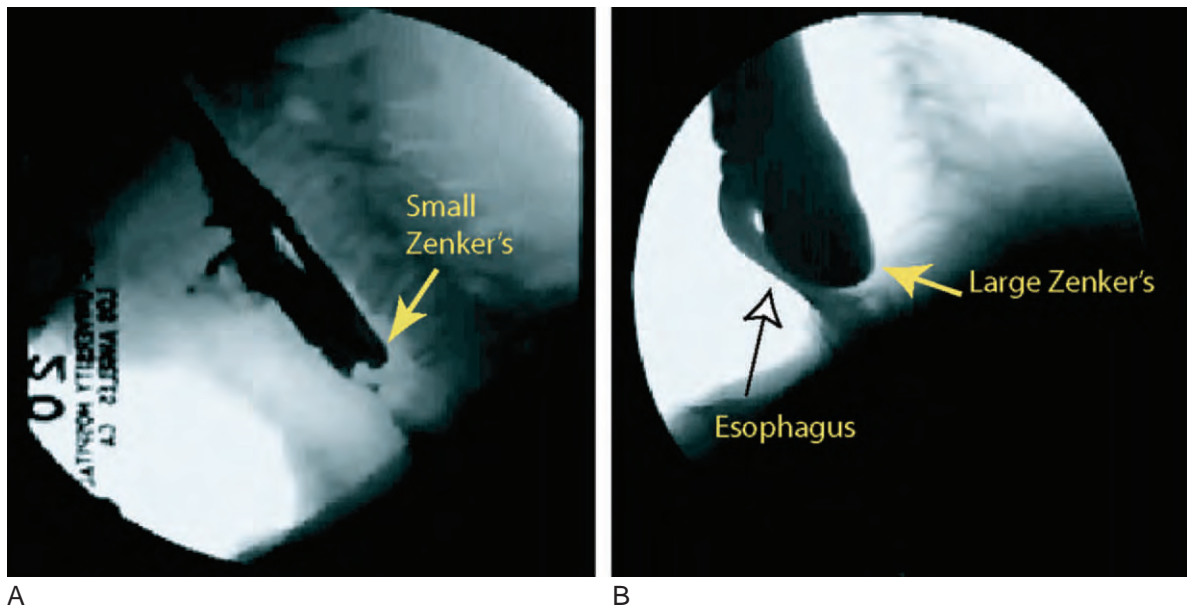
A, Barium contrast roentgenogram of pharyngeal swallowing activity showing a small early Zenker diverticulum. B, If left untreated, a Zenker diverticulum will enlarge and the pouch itself may cause obstruction of the esophagus when filled with swallowed food.
